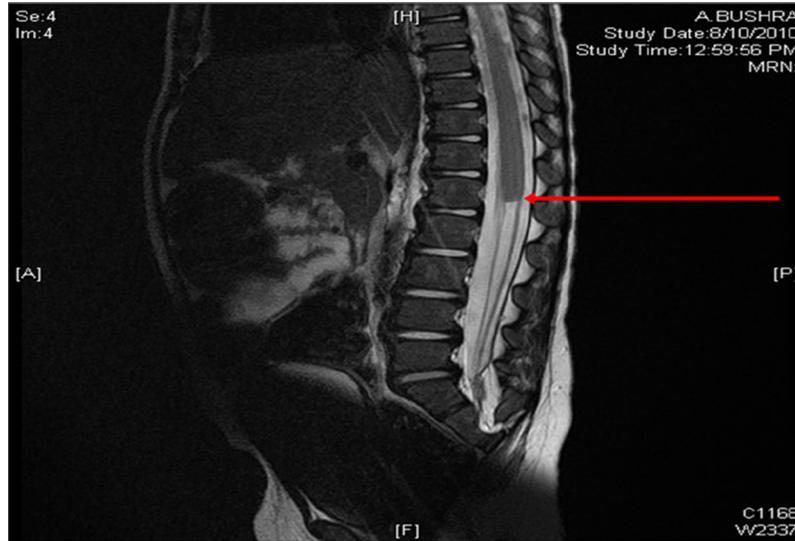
MRI lumbar spine.
